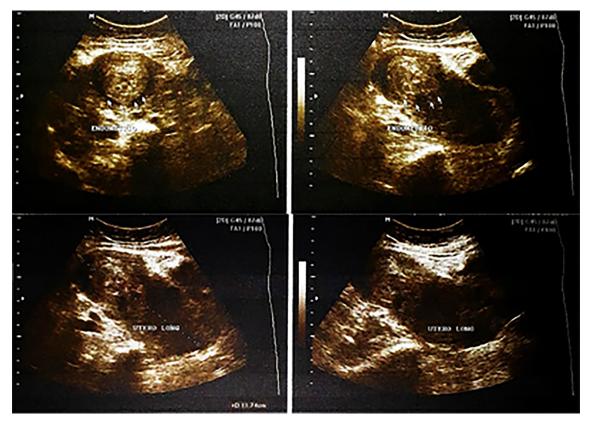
Pelvic ultrasound showing uterus of regular pear-shaped appearance and surface. Increased volume = 178.6cm³, heterogeneous myometrial echotexture, heterogeneous thickening of the cervix, and the sonographic appearance of the endometrium is irregular (25mm, normal = 5mm). Nonvisualized ovaries. Full bladder, regular surface, shape and normal volumes, in ecostructures inside.
